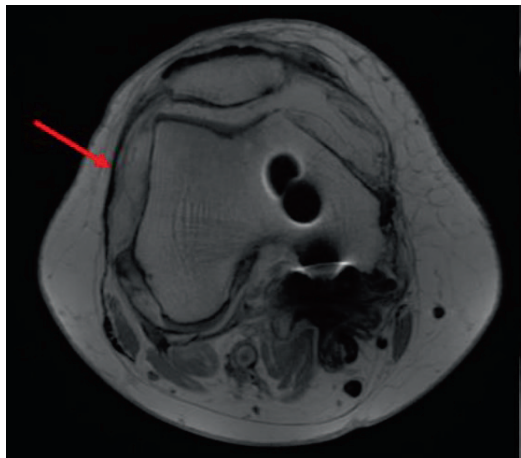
Coronal fast spin echo magnetic resonance image of a patient with osteolysis as indicated by intermediate signal intensity. Patient was revised to a TKR.
